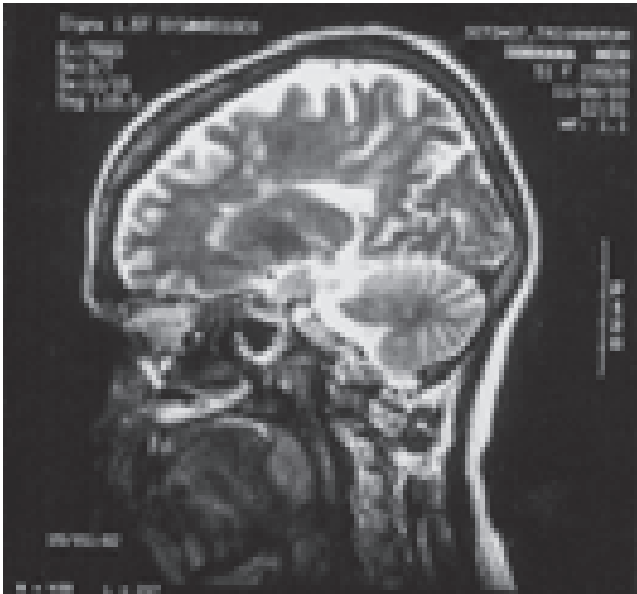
MRI T2 sagittal image after 6 months - most of the lesions have disappeared and there are no new lesions.
